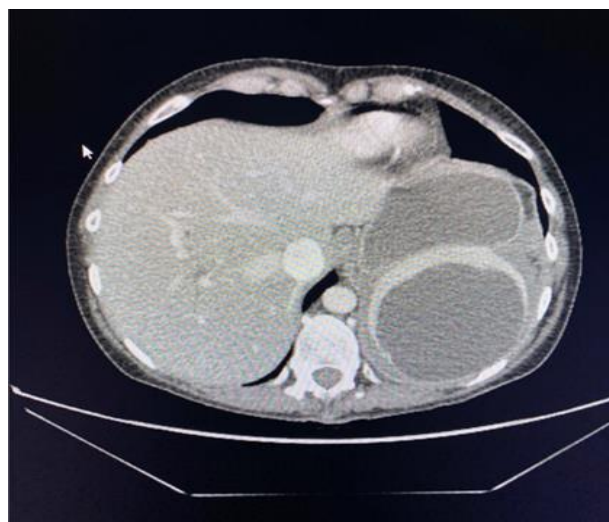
CT Abdomen and Pelvis and IV Contrast (Axial Plane) depicting ruptured pericapsular splenic hematoma.
